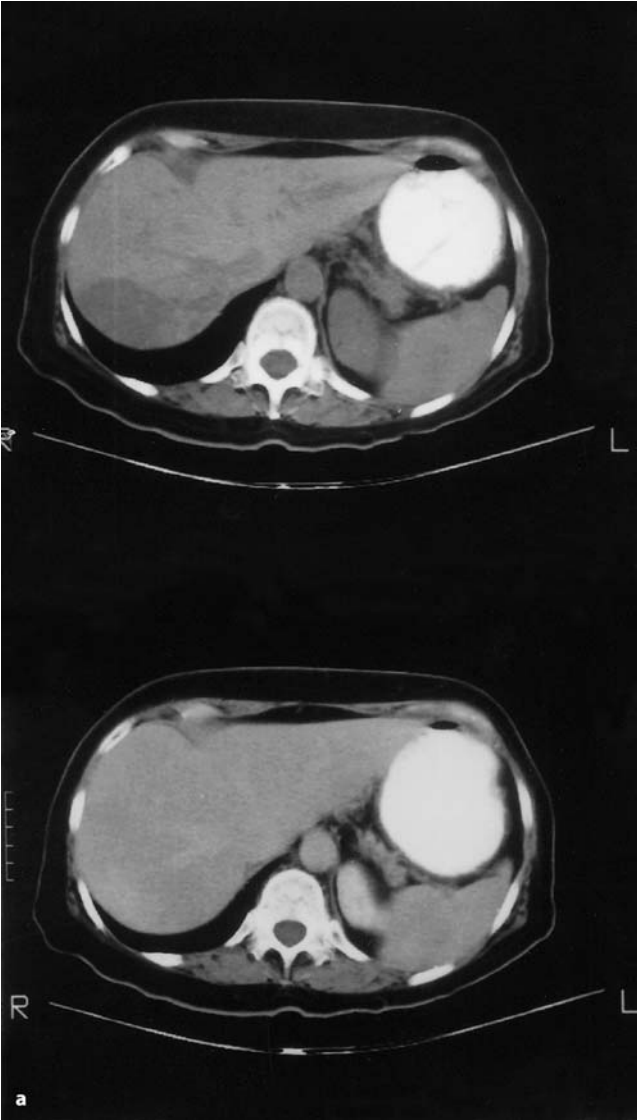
a–c Imaging and therapeutic response with ^{131}I -labeled anti-CEA antibodies in a 72-year-old woman with advanced metastatic MTC (local recurrence and lung, pleural, and liver metastases). a Hypervascular liver metastasis is visible as hypodense lesions in the plain CT scan (*upper panel*) but becomes isointense to the normal liver parenchyma, and thus invisible, in the contrast-enhanced CT scan (*lower panel*)
